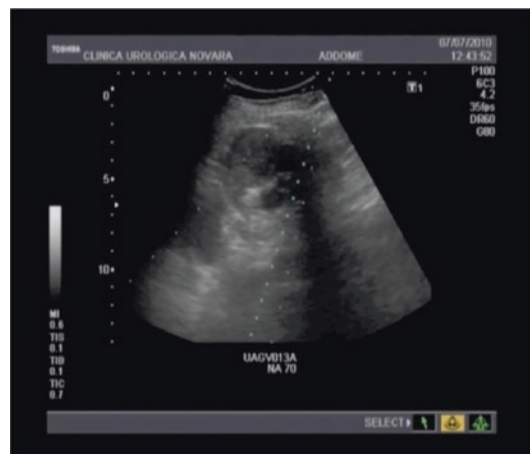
Biopsy of a renal mass under ultrasound guidance
